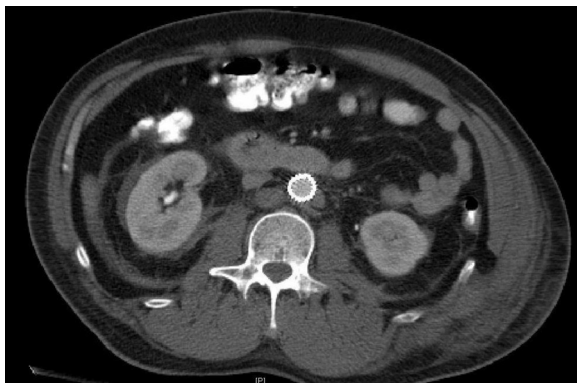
Postprocedure computed tomography (CT) scan with stent graft in place demonstrating resolution of extravasation.
